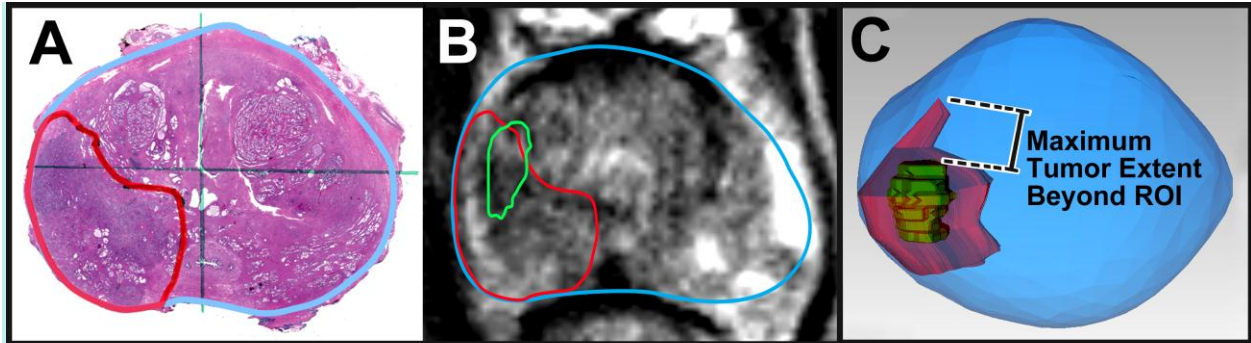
Example co-registration of tumor pathology (A) and MRI (B). Red = pathology, Green = MRI. In C, the irregular contour and maximum extent of the tumor beyond a matched ROI is shown. Significant MRI underestimation of both tumor volume and longest axis is apparent.
